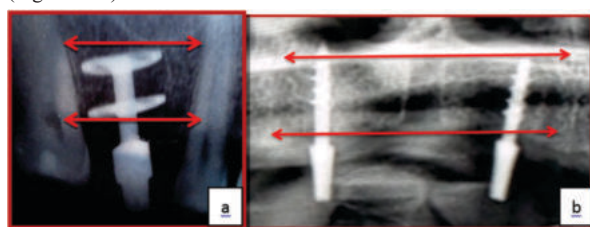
a,b- Radiographs depicting cortical bone engagement by BOI & BCS Implants
